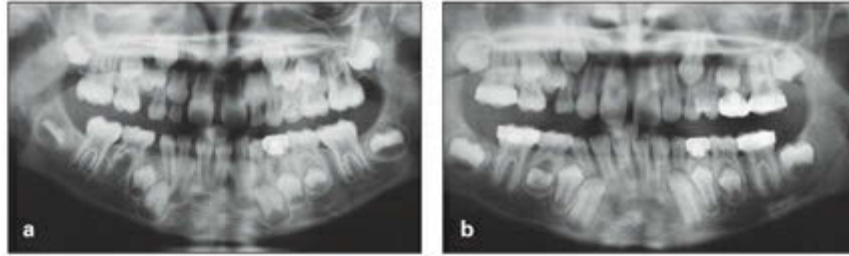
(a) Initial panoramic radiograph, considered to reveal congenital absence of the mandibular right premolar. (b) Panoramic radiograph taken 3 years later, revealing a premolar with retarded formation.
